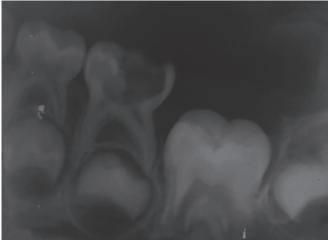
Preoperative intraoral radiograph with respect to 85
